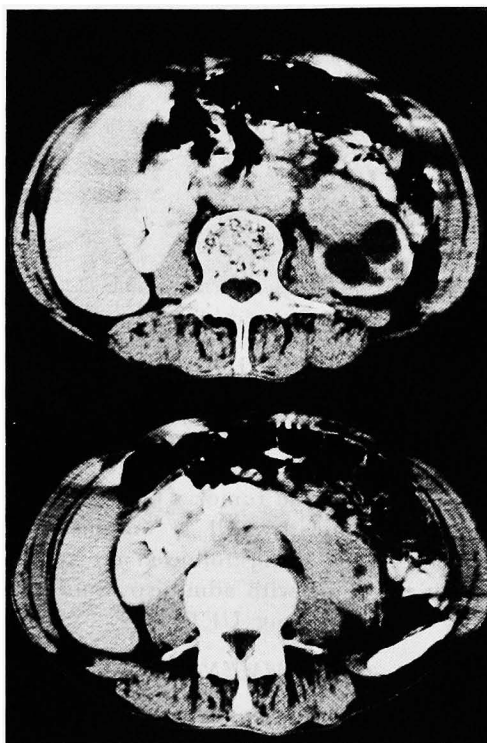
Enhanced CT scan showed a well-defined anteriorly situated renal pelvis mass.
